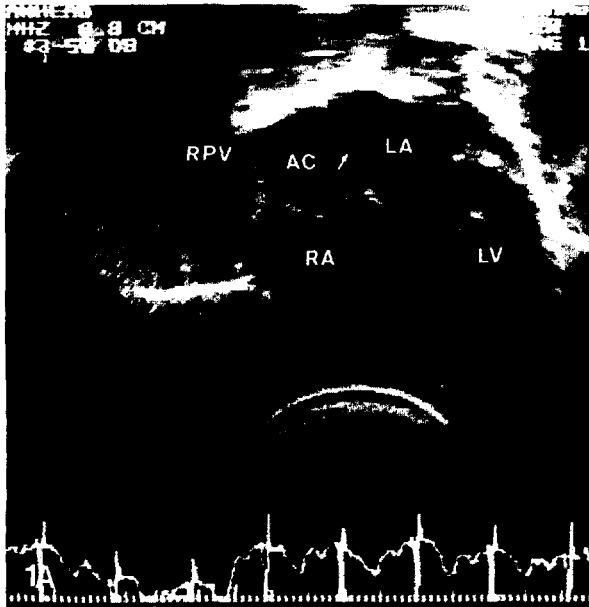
(A) Subxiphoid long-axis echocardiogram demonstrating the intraatrial membrane containing a single orifice (*arrow*) that subdivides the left atrium into a proximal accessory chamber (*AC*) receiving the right pulmonary veins (*RPV*) and a distal left atrial chamber (*LA*). *LV*, left ventricle; and *RA*, right atrium. (B) Levophase of right lower pulmonary artery angiogram demonstrating drainage of right pulmonary vein (*RPV*) to accessory chamber (*AC*) and subsequent filling of distal left atrial chamber (*LA*) via stenotic opening in intraatrial membrane (*arrow*).
